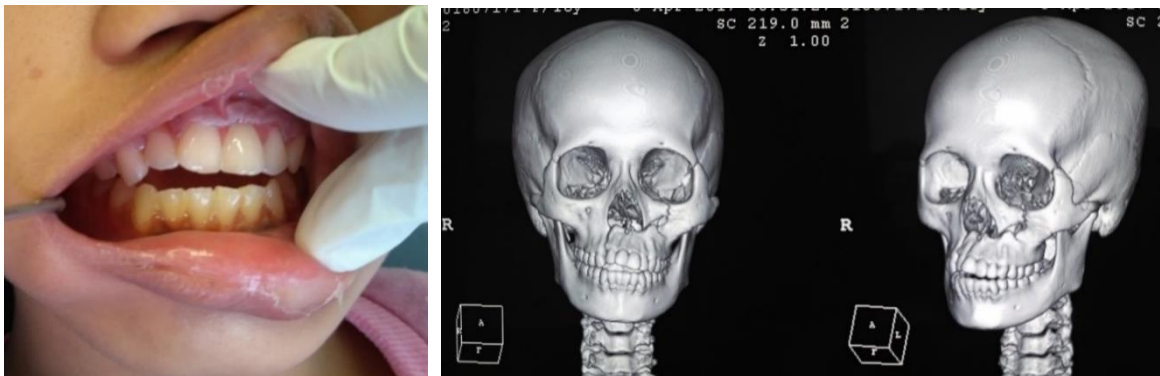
clinical photo and CT scan of the second patient
